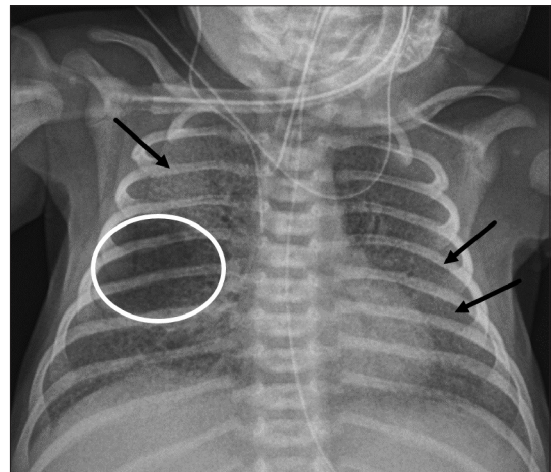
Chest radiograph of a term infant presenting with respiratory distress shows diffuse hazy airspace opacities (black arrows) and a pneumatocele (white outline). The patient was suspected to have a surfactant deficiency disorder and found to have adenosine triphosphate-binding cassette transporter protein A3 mutation
